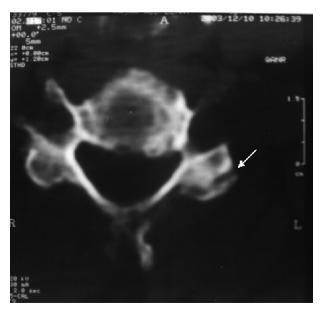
Cut CT scan of cervical spine showin; facet joint narrowing (arrowed).
